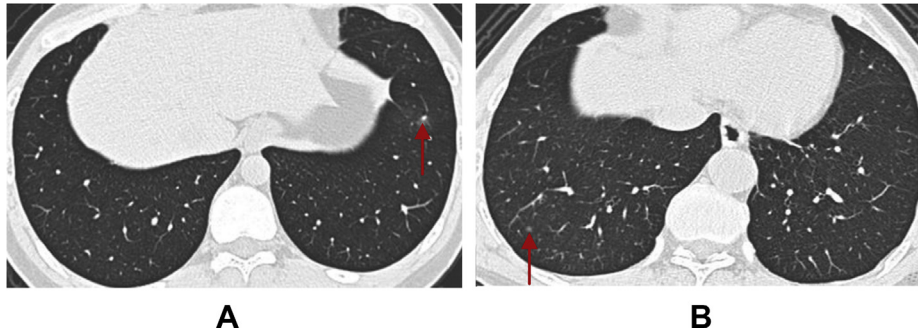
Male patient, 23 years old; Clinical manifestations of fever, dry cough for 5 days, and fatigue for 2 days; relevant contact history; CT examination; no obvious signs of pneumonia were seen in either lung (see the red arrows).
